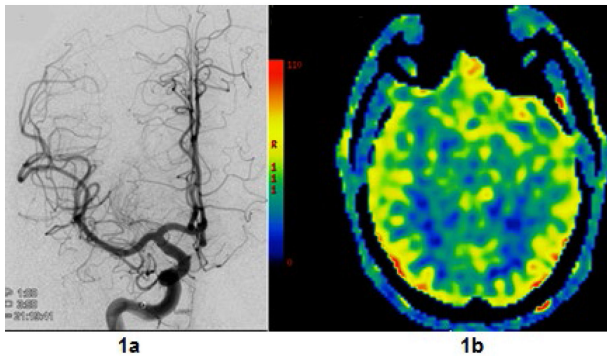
showing normal digital subtraction angiogram (DSA) without any evidence of vasospasm. Figure 1b showing normal ASL imaging: there is a symmetric flow between the two hemispheres, cortical gray matter exhibits slightly higher signal intensity than white matter from using the same coefficient called baseline magnetization artifact. High signal intensity in the occipital region is due to an activation of the visual areas in the MRI environment. (The tagged image and the control image are subtracted to produce a perfusion image which is expressed in units of mL/100 g/min.)
